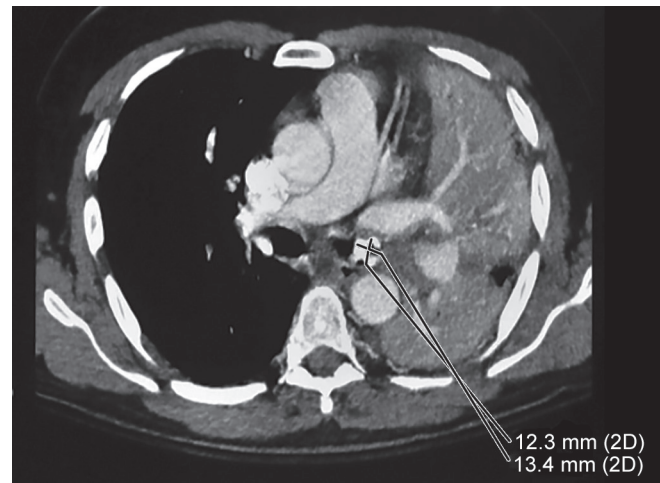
High-resolution computed tomography scan (HRCT) axial cut shows a 12 × 13 mm foreign body, about 19 mm distal to carina lodged in the left main bronchus
